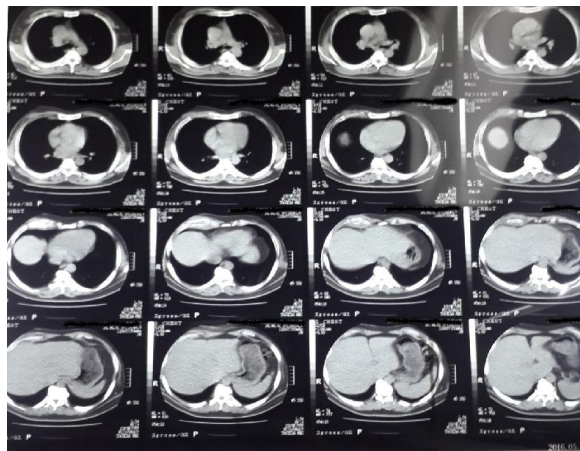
Initial CT scan
